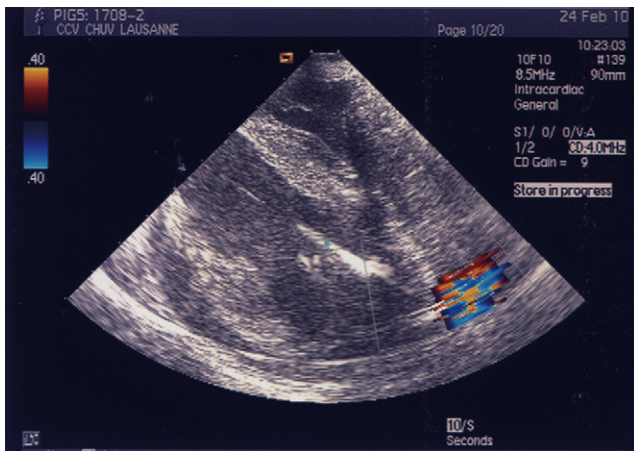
After the ventricular septal access was dilated with 18F and oversized dilators, an obvious blood shunt from left ventricle to the right ventricle can be demonstrated with ICE and the colour-Doppler.
